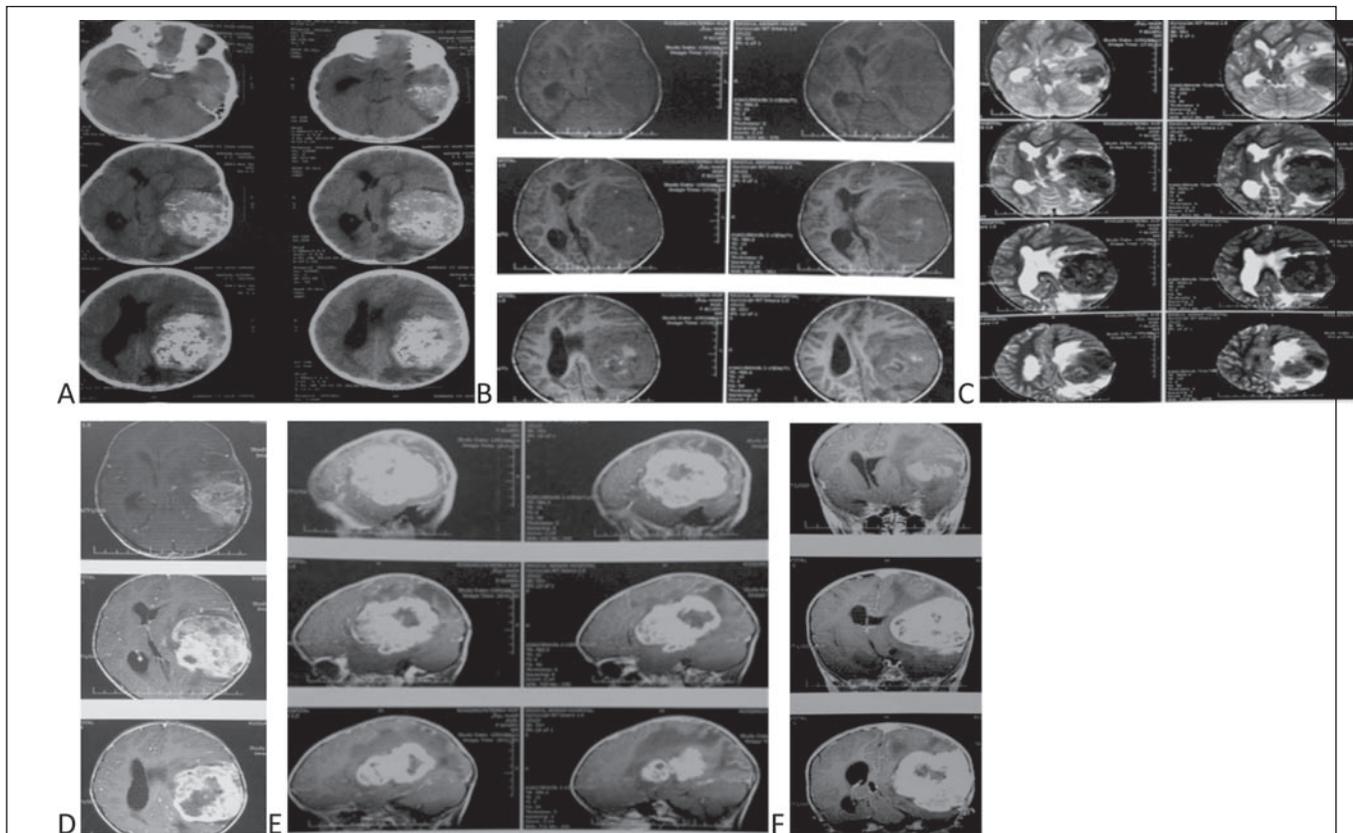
The brain imaging showed the tumour features: (A) The brain non contrast CT scan; (B) T1 sequence MRI; (C) T2 sequence MRI; (D) Axial T1 with Gadolinium (Gd) injection MRI; (E) Sagittal T1 with Gd injection MRI and (F) Coronal T1 with Gd injection MRI.
